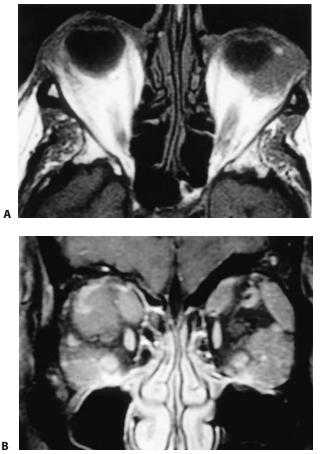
Magnetic resonance images in a patient with largecell lymphoma demonstrate multiple intraorbital masses infiltrating the lacrimal gland and the extraocular muscles. (A) Axial noncontrast T1-weighted image. (B) Coronal fat-suppressed, contrast-enhanced T1-weighted image.
